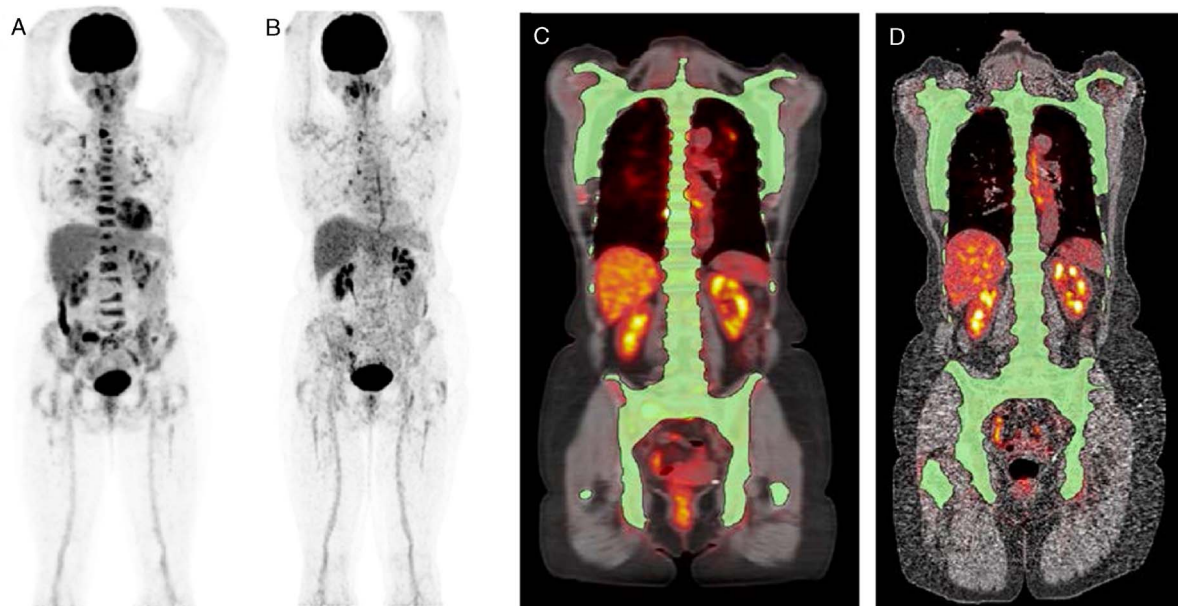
A 51-year-old female healthy volunteer. Dynamic scan was acquired for 60 minutes after injection of 348 MBq of FDG. A, Reconstruction of the last 20 minutes of dynamic acquisition; (B–F) 20-minute duration scans obtained at 90 minutes, and 3, 6, 9, and 12 hours after injection. Patient was fed with high-protein snack after the 3-hour scan. Reproduced with permission from PET Clinics.<sup>61</sup>
